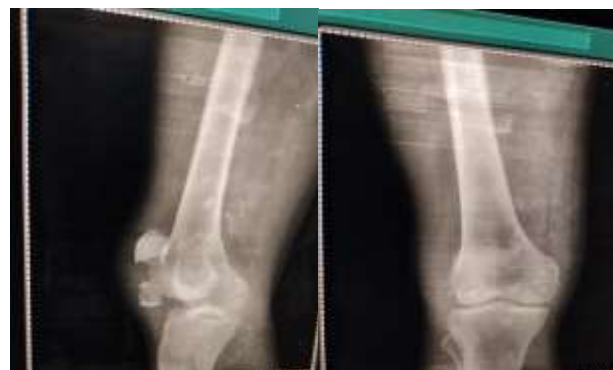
Postoperative X-ray with encircage.
